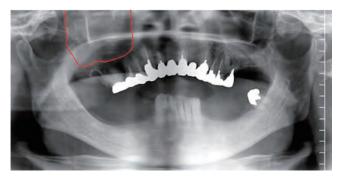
Sinusitis. X-ray of panoramic view. Cloudy right maxillary antrum
